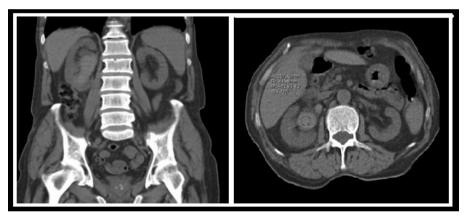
Hyperdense space-occupying lesion extending from the right renal pelvis to the lower calyx in the coronal and axial sections of the computed tomography
